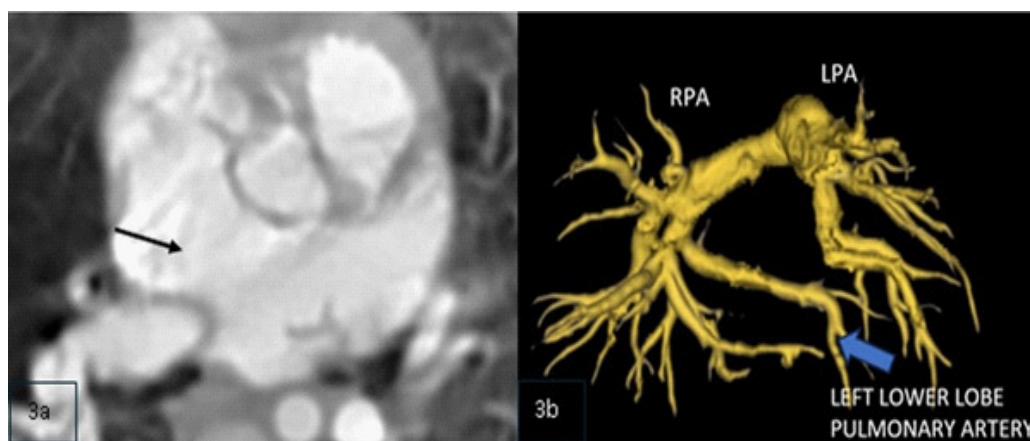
(a) Axial image shows a large atrial secundum defect (line arrow). (b) 3D volume-rendered computed tomographic angiography shows anomalous origin of the left lower lobe pulmonary artery from right descending pulmonary artery. RPA =Right pulmonary artery. LPA= Left pulmonary artery.
